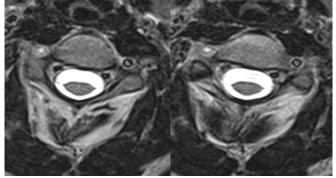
Cervical MRI, axial sequences at C5-C6 level, showing normal flow in the left VA and absence of flow in the right VA, corresponding to VA occlusion
